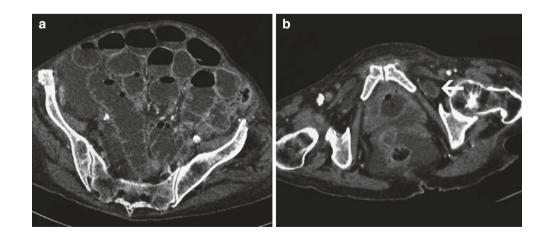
Axial CT scans demonstrating small bowel obstruction (a) secondary to a clinically occult left-sided obturator hernia (b)
